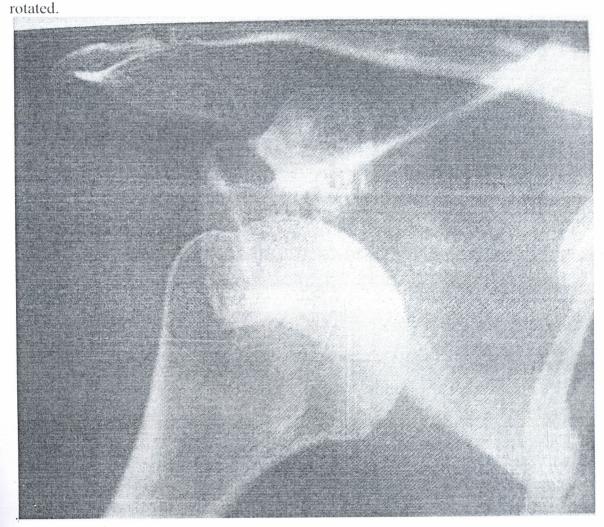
Typical radiographic appearance in anterior dislocation of shoulder
